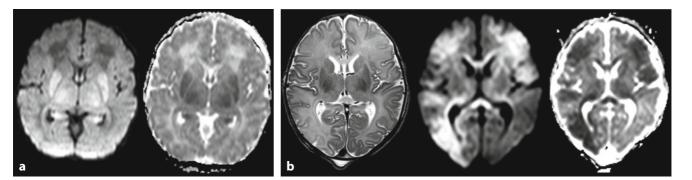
MRI of two full-term neonates with perinatal asphyxia. a Abnormalities of the basal ganglia and thalamus on the 4th day of life in a full-term neonate with perinatal asphyxia: DWI (*left*) and ADC map (*right*). ADC values of the basal ganglia were 770×10^{-6} mm²/s. The patient died 5 days after birth. b Abnormalities of gray and white matter in a full-term neonate with watershed infarcts. MRI on day 3 after birth. T2 weighted (*left*), diffusion weighted (*middle*) images, and ADC map (*right*). This infant showed normal development at 1 year of age
